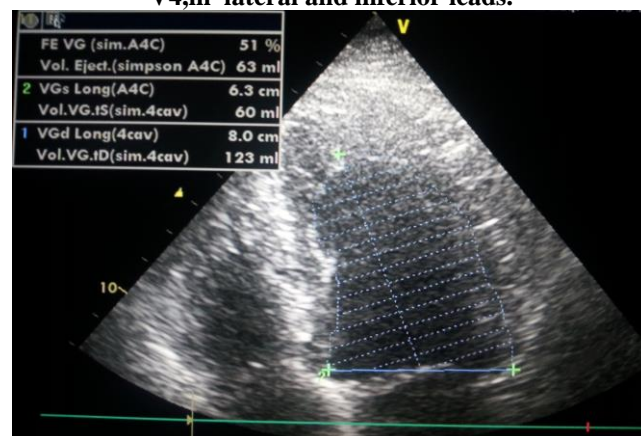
Transthoracic echocardiography: an apical four-chamber view showing preserved left ventricular systolic function (51%).
